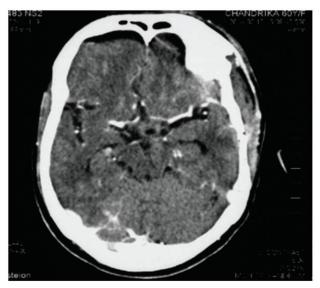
Two months post-operative contrast Computed Tomogram brain showing resolution of both the lesion and hemorrhage
